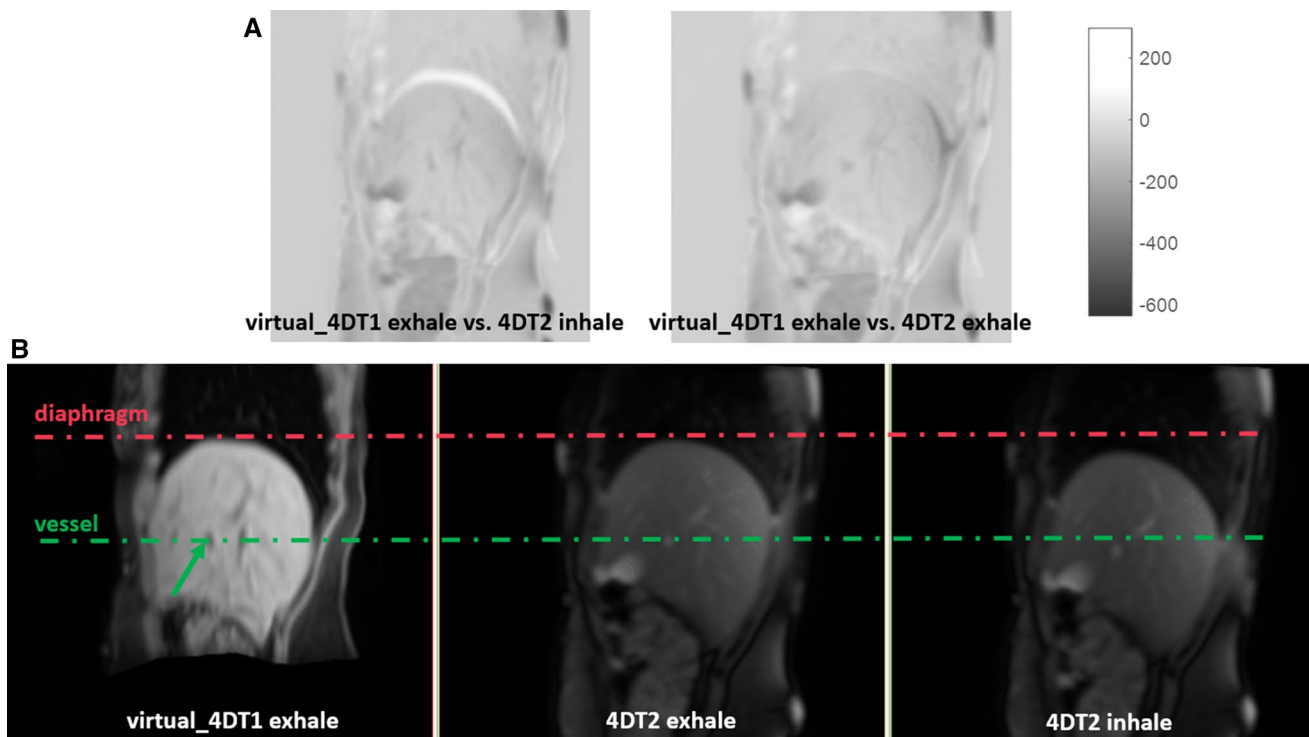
shows the *virtual\_4DT1* at the exhale phase for a representative volunteer. The derived *virtual\_4DT1* at the exhale phase compensated for the motion derived from the *4DT2*. Both diaphragm and vessels resulted closer to the *4DT2* at the exhale phase. No comparison was made with the 4D T1-weighted derived with FLASH, due to its limited contrast in the definition of internal structures.
